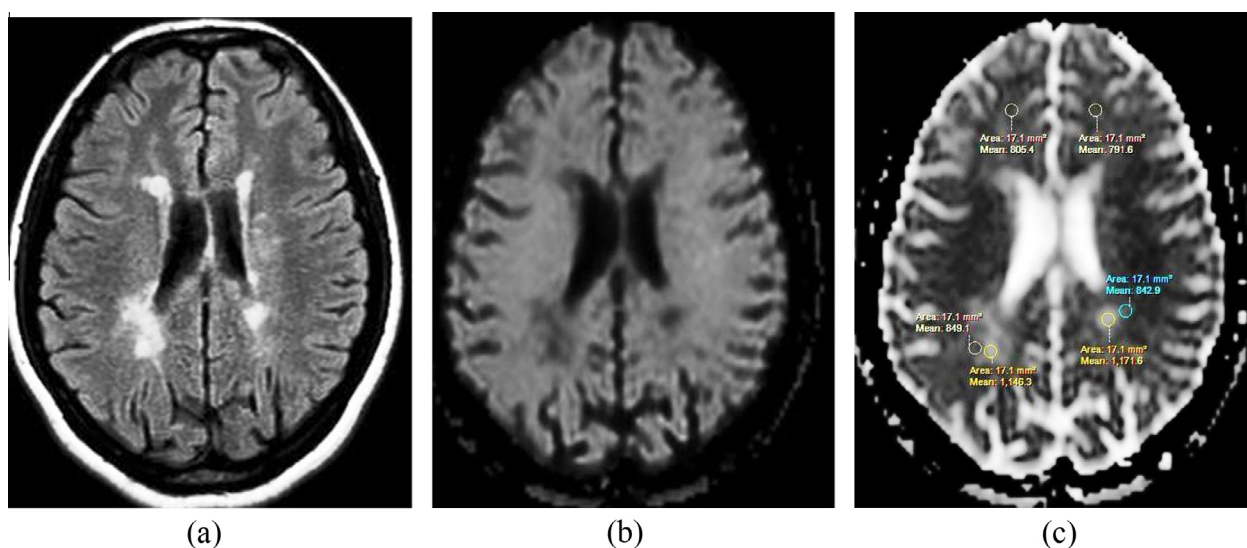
40-year-old female patient with RRMS and no cognitive impairment (MOCA score 26). (a) Axial FLAIR showed multiple plaques, (b) DWI image showed signal intensity of facilitated diffusion, (c) ADC map showed the following readings: Plaque 1.1643×10^{-3} , Peri-plaque 0.8491×10^{-3} and NAWM $0.8054 \times 10^{-3} \text{ mm}^2/\text{s}$.
